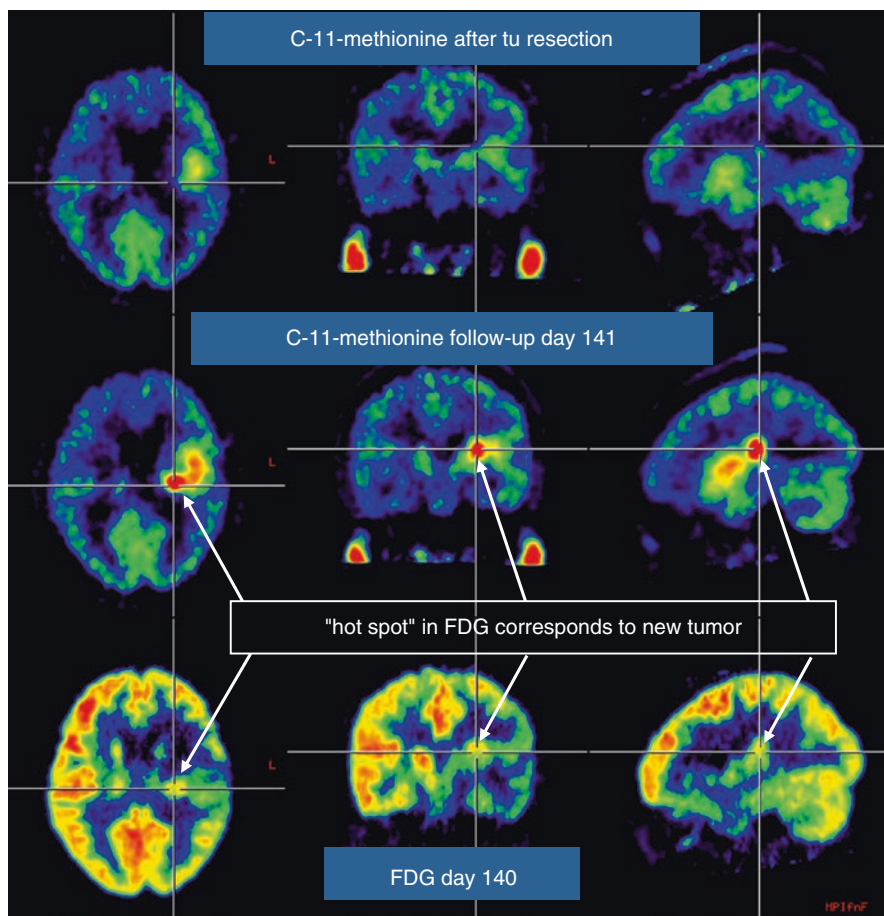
Comparison of MET PET and FDG in recurrent glioblastoma. Within a few weeks after macroscopically complete tumour resection, MET PET is already showing increased uptake in the resection area (top row), which increases in intensity during the next 3 months (middle row), when the recurrence is also identified with less signal intensity on FDG PET (bottom row)
